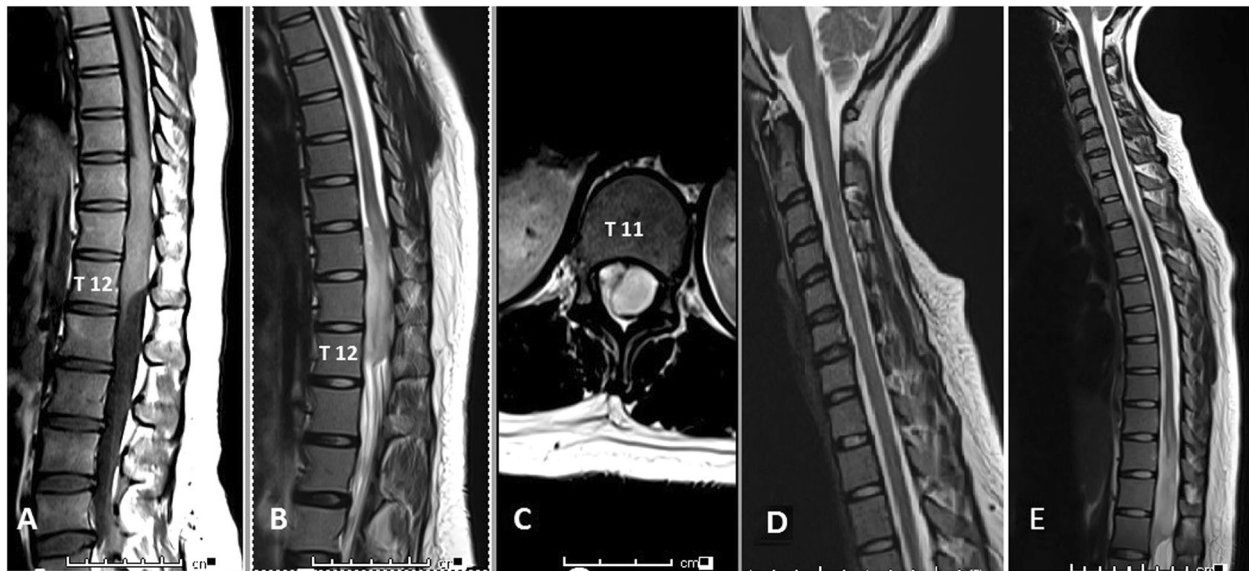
Plain MRI of the spine showing an intramedullary lesion in the region of the conus. a Sagittal T1-weighted image showing an isointense lesion extending from T10 to T12, b Sagittal T2-weighted image demonstrating the lesion to be hyperintense. A ventrally
